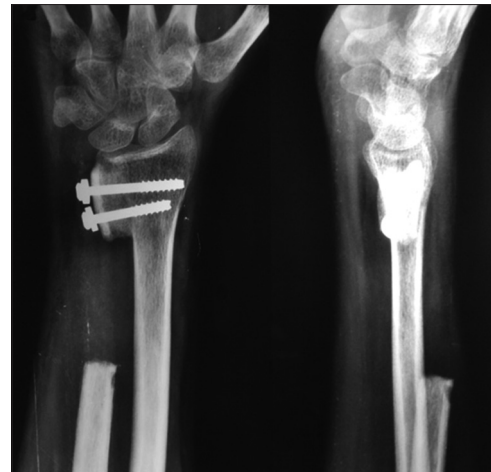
Post-operative radiograph after 3 months showing union of the graft to the distal radius
